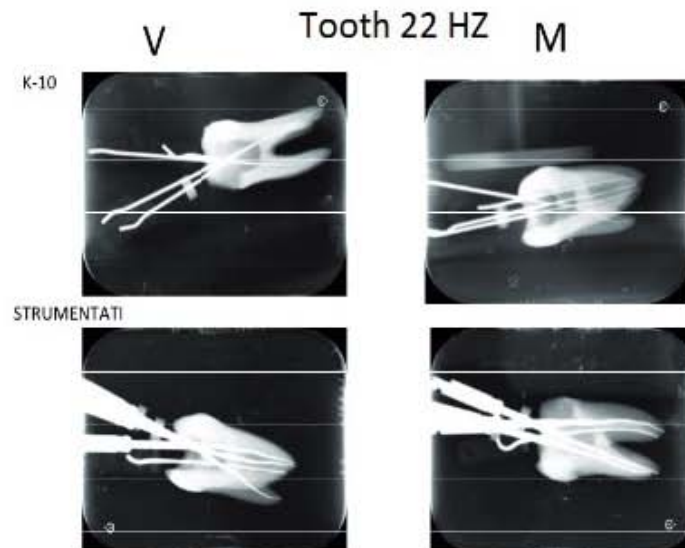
Pre- and postoperative radiographs of a molar treated with Horizon instruments.
